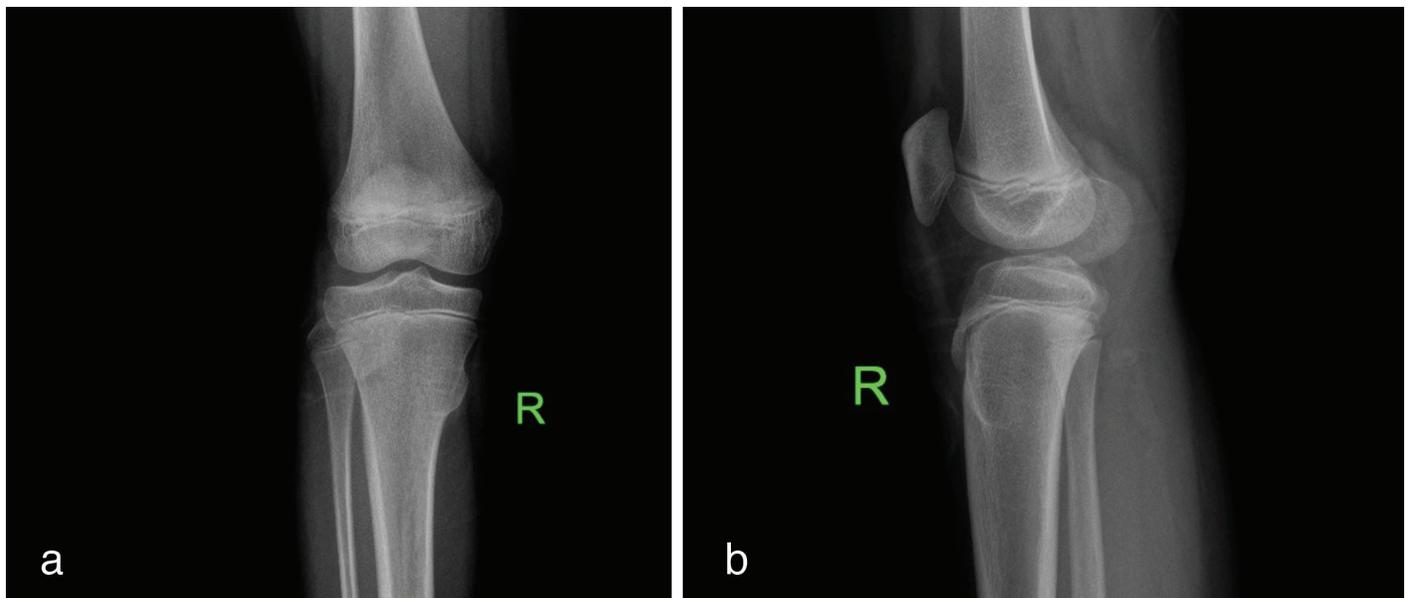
Knee radiographs of a 15-year-old patient show an osteochondroma of the proximal part of the tibia
